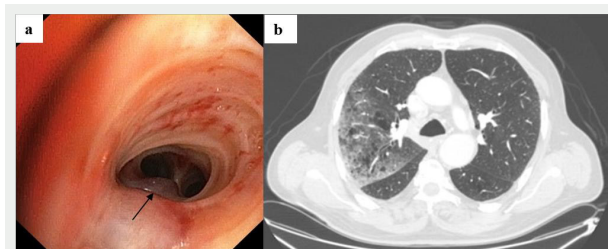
(a) Protruding polypoid formation in the right upper lobar apical bronchus (black arrow) (endo-bronchial metastasis of renal cell carcinoma). (b) Axial slice in lung parenchyma window of a thoracic computed tomography scan showing ground-glass opacities in the right upper lobe (site of bleeding).
